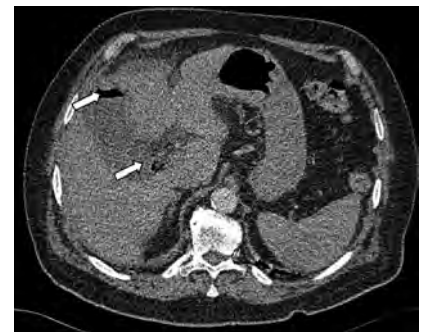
Computed tomography angiography showing gas in the biliary tree (arrows).
